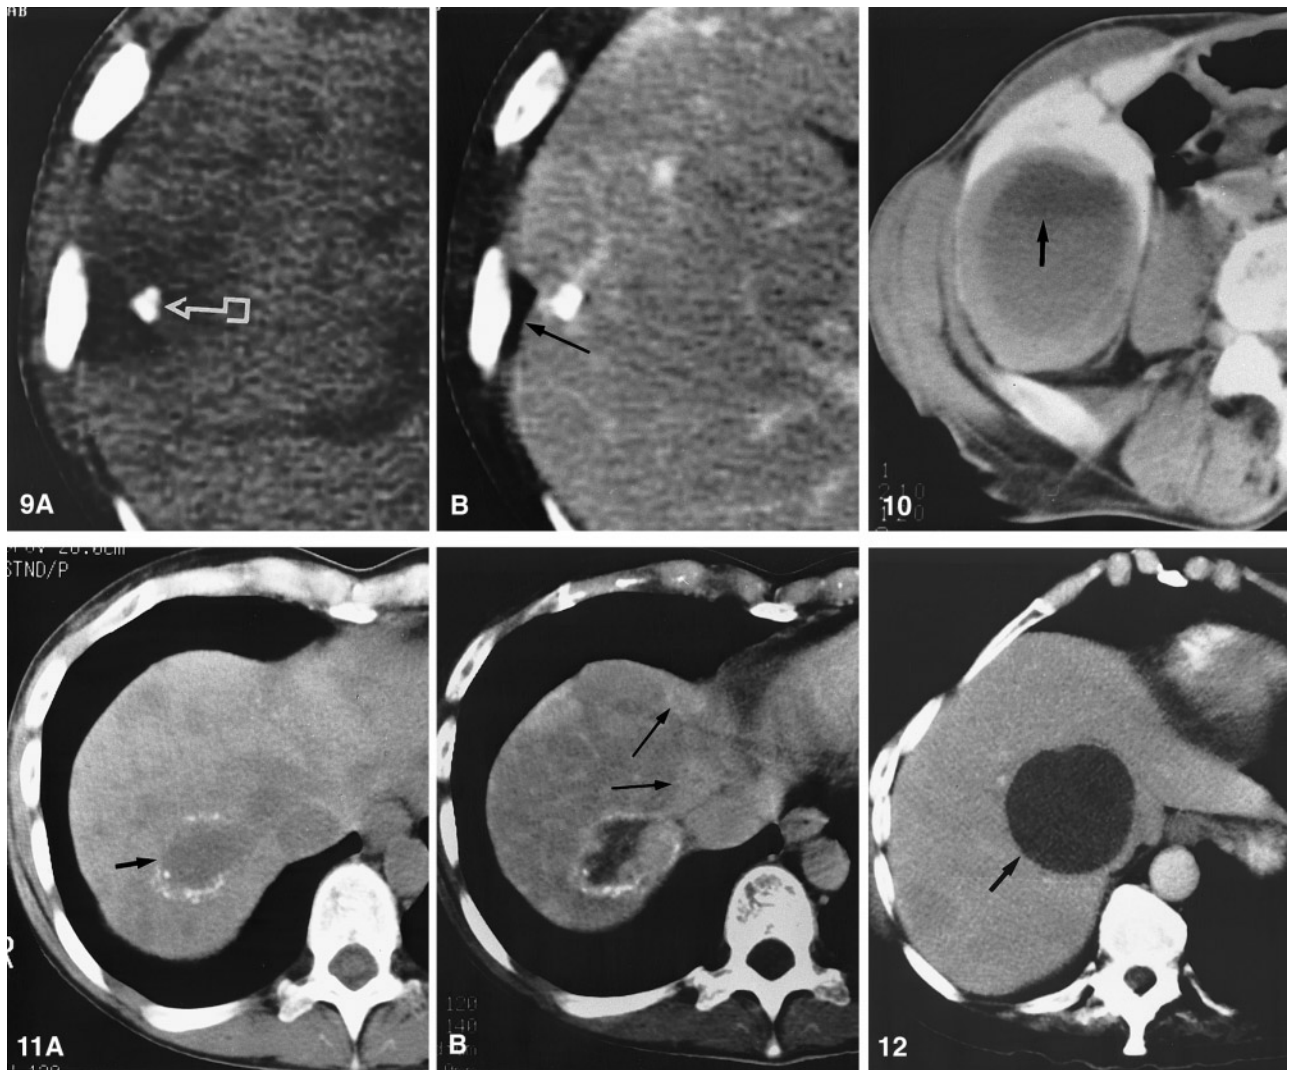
A 60-year-old man who had intraarterial chemotherapy because of unresectable hepatic metastases from carcinoid tumor. A Unenhanced CT shows hypoattenuating lesion that contains calcification (*arrow*). B After intravenous administration of iodinated contrast material, retraction of the liver capsule is seen adjacent to the tumor (*arrow*).
